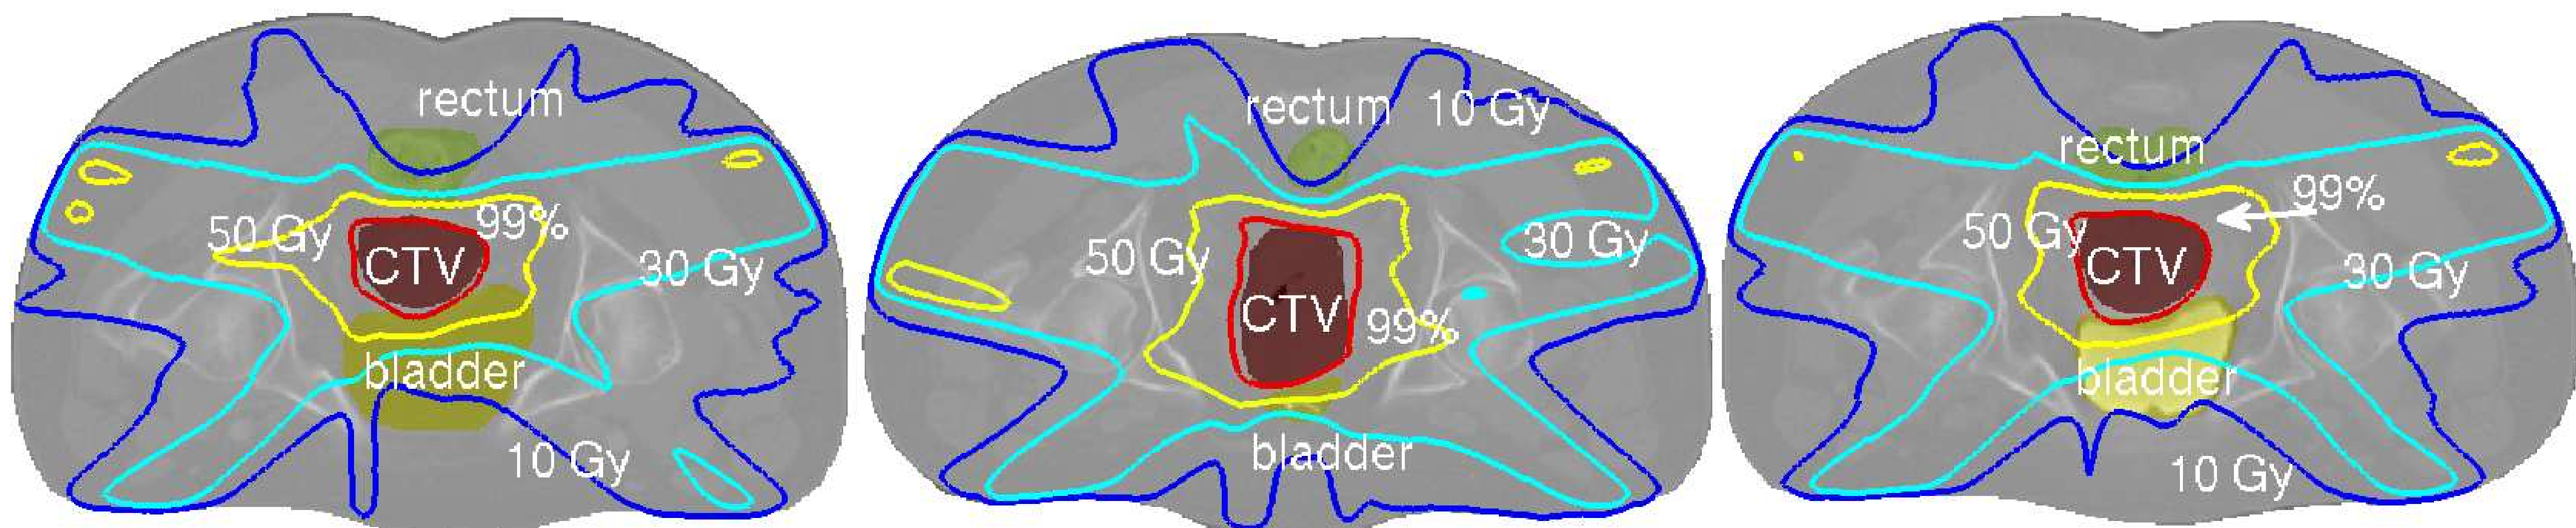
Dose distributions for the cervix-uterus case. Depicted are the CTV, rectum and bladder and isodose lines for 99% (red) of the prescribed dose, 50 Gy (yellow), 30 Gy (cyan) and 10 Gy (blue). The bladder filling changes significantly: the volume for the planning CT (left) was 234 cc, 31 cc for the 1st fraction (middle) and 78 cc for the 2nd fraction (right). Despite the large bladder volume changes and CTV deformations, the dose adjusts accordingly.
